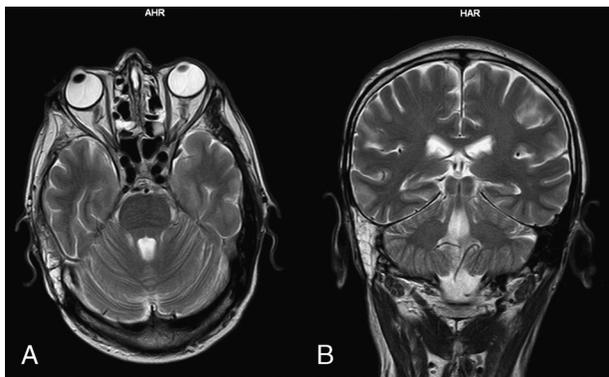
Axial, T2-weighted, MRI scans obtained after resolution of the syndrome. No significant abnormalities are observed apart from postsurgical changes.
